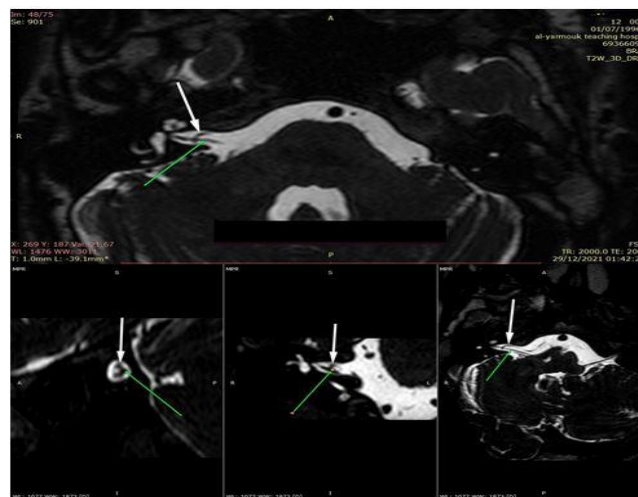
MRI of a 27-year-old male presented with headache, a T2 3D DRIVE sequence with axial, sagittal, and coronal views demonstrate a vascular loop (white arrow) passing adjacent to the vestibulocochlear nerve
